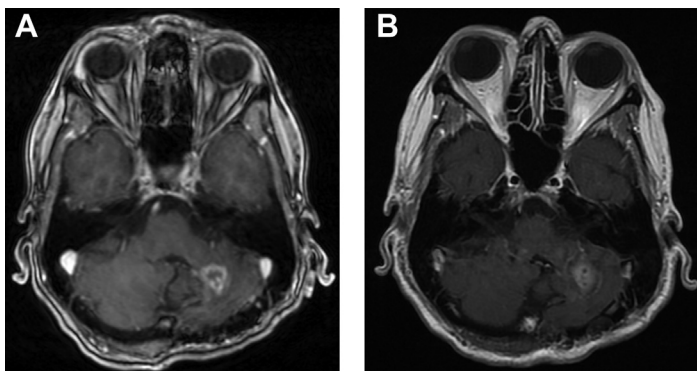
(A) T1-weighted MRI demonstrating recurrent ovarian metastasis in the left cerebellum. (B) Post-LITT T1-weighted MRI demonstrating total lesional ablation.
